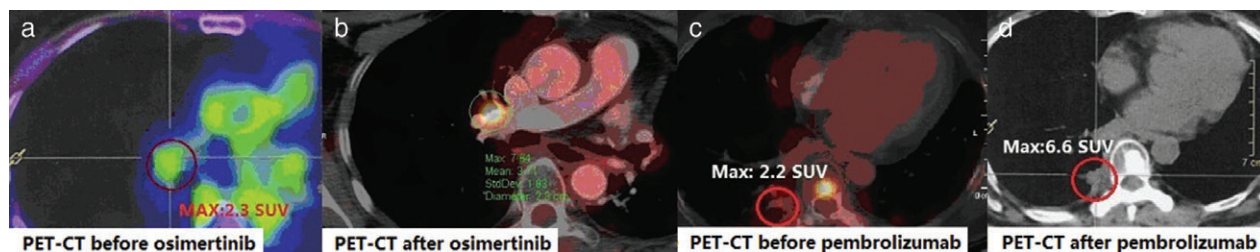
Positron emission tomography-computed tomography (PET-CT) taken (a) before and (b) two months after osimertinib administration, demonstrating higher 18F-fluorodeoxyglucose (FDG) uptake in the right hilar lymph node (standardized uptake value [SUV] 7.64) after treatment. PET-CT taken (c) before and (d) after three cycles of pembrolizumab plus cisplatin-pemetrexed, showing increasing 18F-FDG uptake of the right pleural mass (max SUV value 6.6) after treatment.
